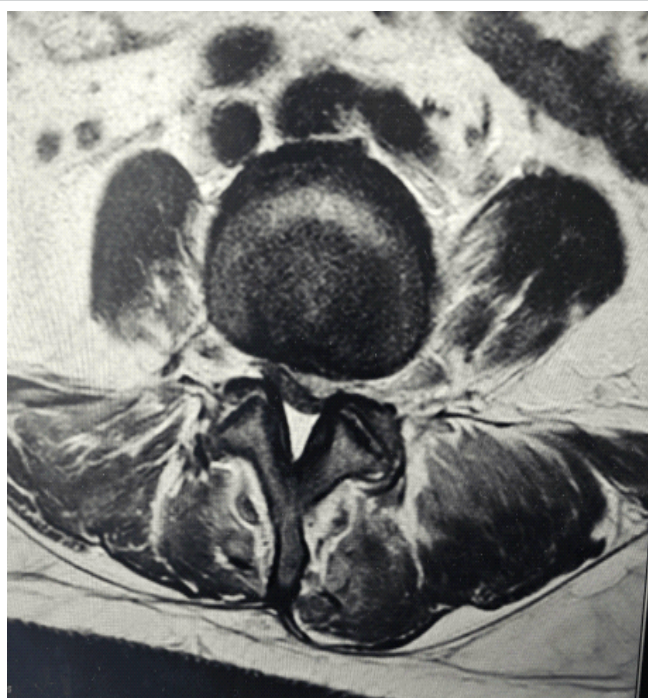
Axial magnetic resonance imaging demonstrating posterior epidural collection causing compression of the thecal sac at the lumbosacral level.
